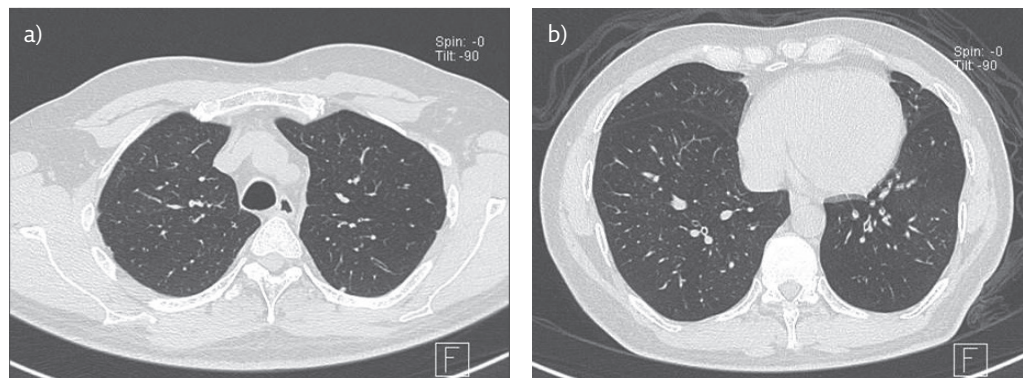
a and b) HRCT of the thorax showing complete radiological resolution of the patchy areas of consolidation.
